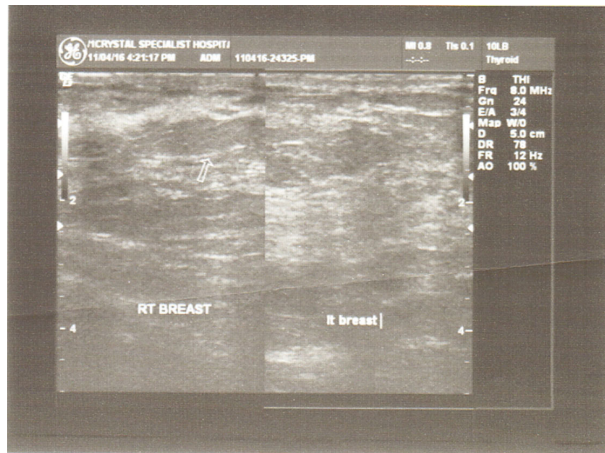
Normal breast tissue in sagittal plane with high level echoes, with no change to surrounding architecture (mass-free). Note the Doppler exposure on “B” (right) arrowed. More (breast) fibrous tissue in the parenchyma seems to generate higher echogenicity.
